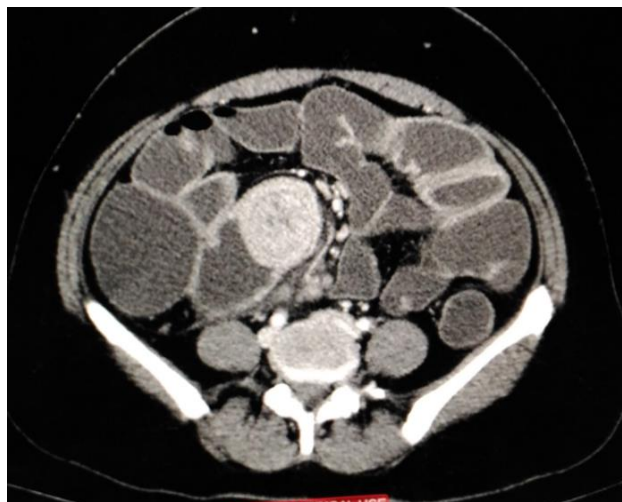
CT Abdomen showing target sign at ileocecal junction.
